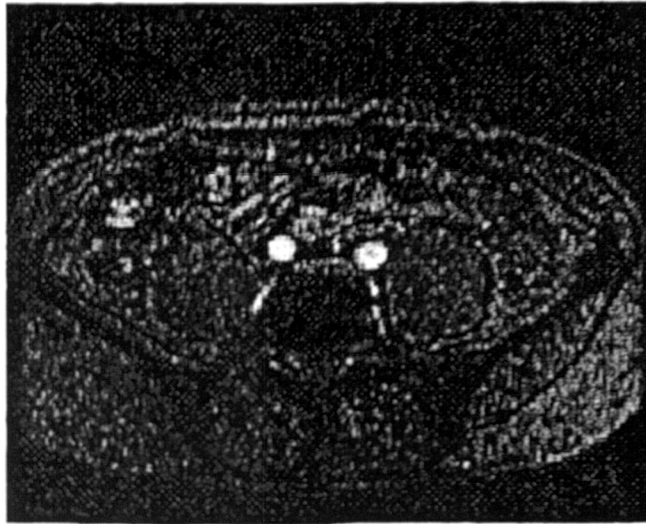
Original 2D TOF MR image acquired in the iliac arteries of a human subject.
